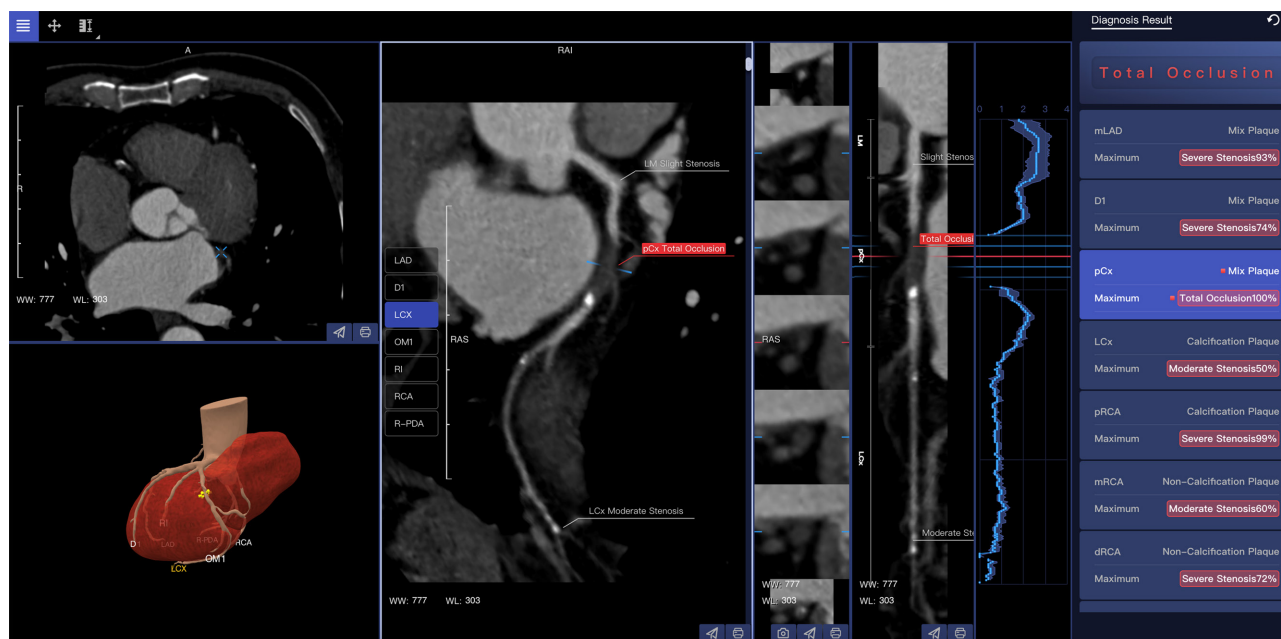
Example of the lesion detection of the proposed AI-assisted CCTA method. A chronic total occlusion lesion in the proximal segment of LCX was automatically detected, and the reports are generated automatically. WW, window width; WL, window level; LAD, left anterior descending artery; D1, first diagonal branch; LCX, left circumflex artery; OM1, first obtuse margin branch; RI, ramus intermedius; RCA, right coronary artery; R-PDA, right posterior descending artery; LM, left main coronary artery; pCx, proximal segment of the LCX; mLAD, middle segment of the LAD; pRCA, proximal segment of the RCA; mRCA, middle segment of the RCA; dRCA, distal segment of the RCA; AI, artificial intelligence; CCTA, coronary computed tomography angiography.
